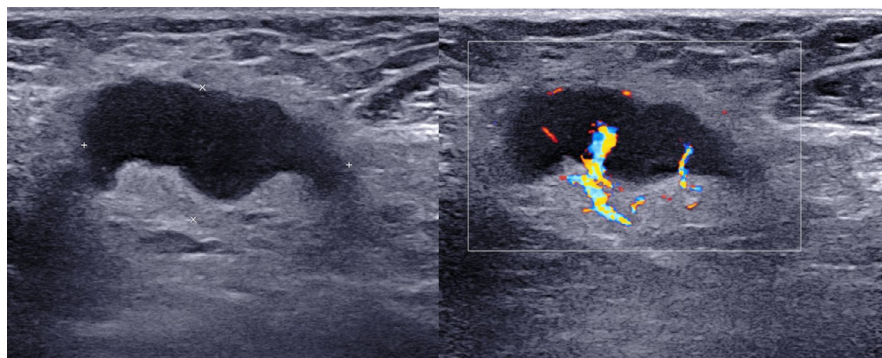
Sonography shows a 3.0x1.5-cm lobulated heterogeneous hypoechoic lesion with internal vascularity in the right axilla [Color figure can be viewed at wileyonlinelibrary.com]
